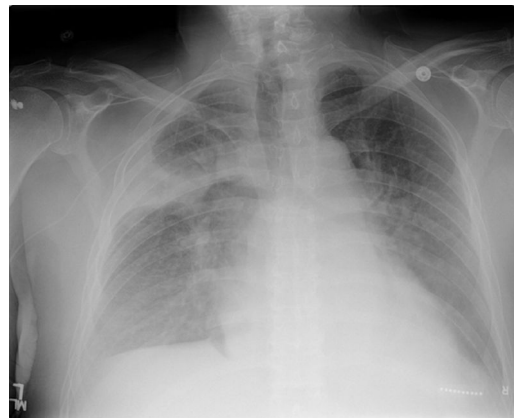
Chest radiograph shows infiltrates in the right lung fields.
